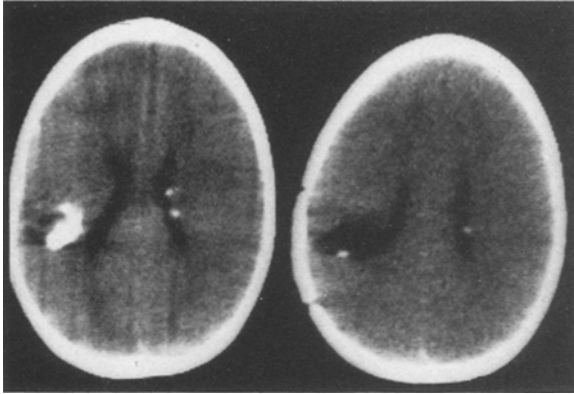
Tuberosclerosis with intra- and paraventricular astrocytoma (H.K. 081269/1982) below the angular region. Intersylvic, intergyral persulcal approach and removal, pre- and post-operative CT. Normal course over 3 years
